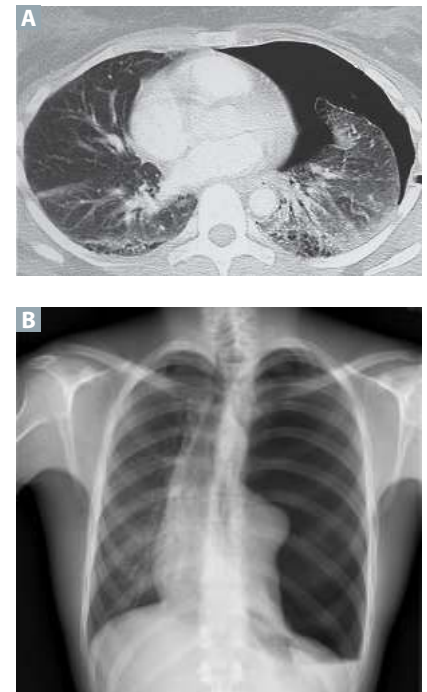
Pneumothorax. (A) Pneumothorax. CT shows collapsed left lung. (B) Tension pneumothorax. (Image A reproduced with permission from Miura K, Kondo R, Kurai M, et al. Birt-Hogg-Dubé syndrome detected incidentally by asymptomatic bilateral pneumothorax in health screening: a case of a young Japanese woman. *Surg Case Rep.* 2015;1:17. doi:10.1186/s40792-015-0014-8. Image B reproduced with permission from Rosat A, Díaz C. Reexpansion pulmonary edema after drainage of tension pneumothorax. *Pan Afr Med J.* 2015;22:143. doi:10.11604/pamj.2015.22.143.8097.
